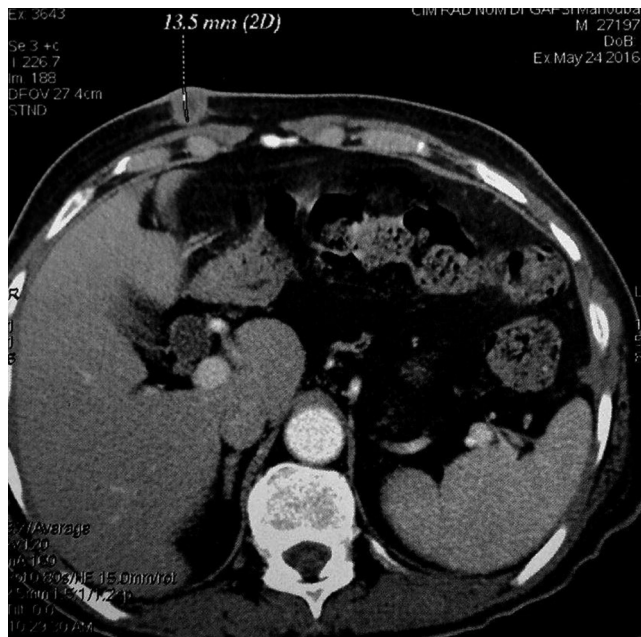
CT scan showing subcutaneous nodule extending to the anterior abdominal wall.
